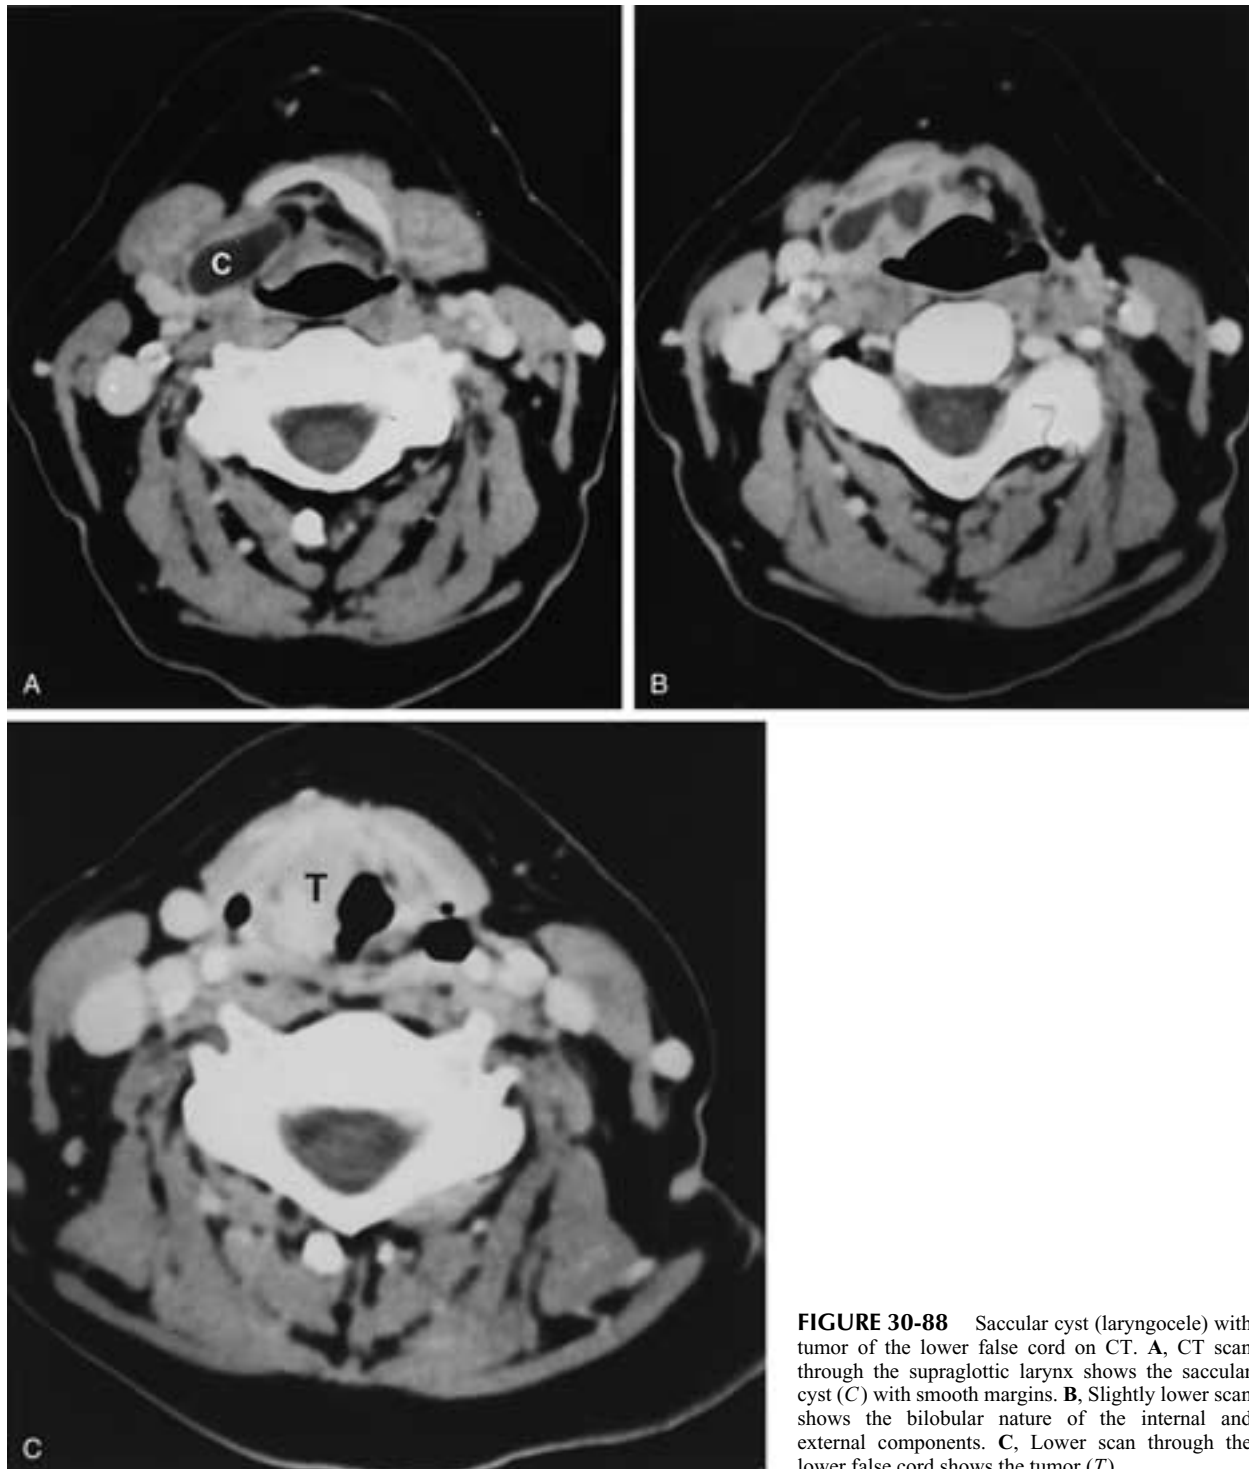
Saccular cyst (laryngocoele) with tumor of the lower false cord on CT. A, CT scan through the supraglottic larynx shows the saccular cyst (*C*) with smooth margins. B, Slightly lower scan shows the bilobular nature of the internal and external components. C, Lower scan through the lower false cord shows the tumor (*T*).
